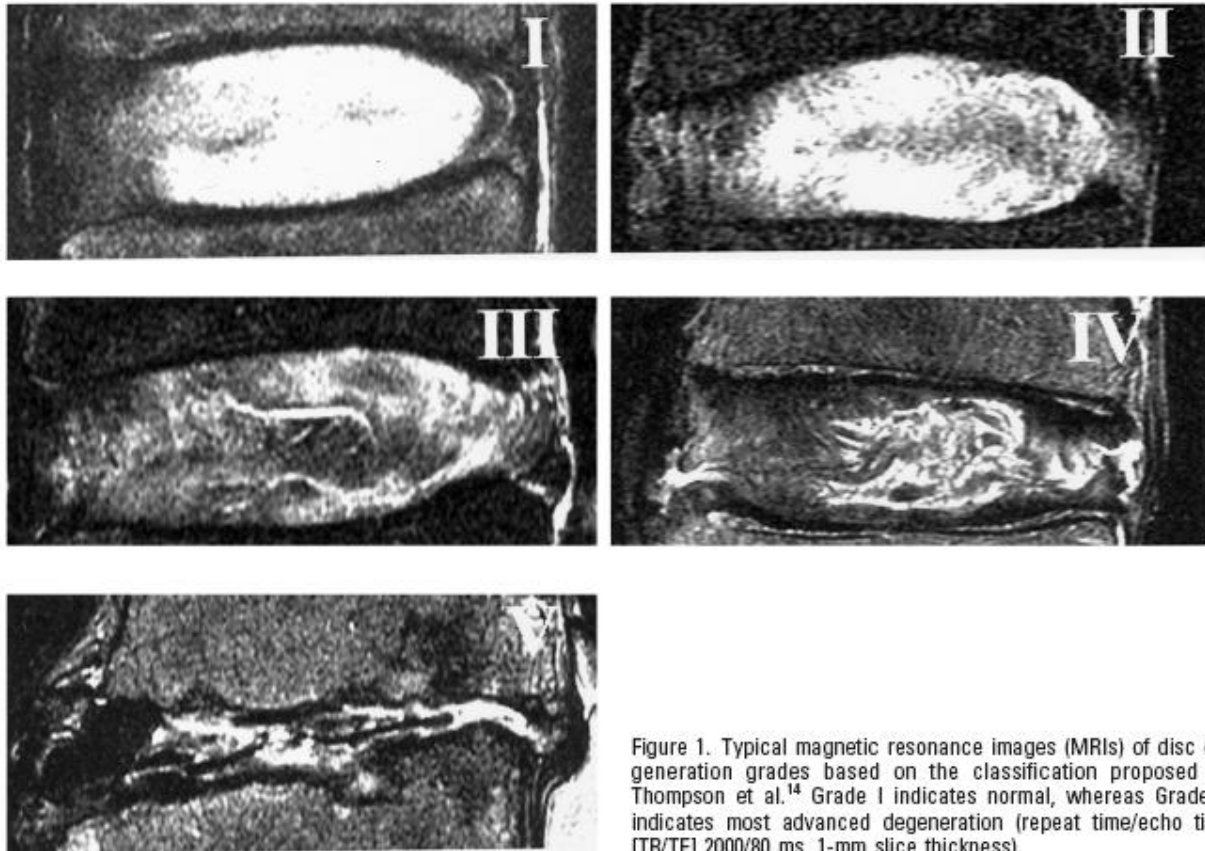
Typical magnetic resonance images (MRIs) of disc degeneration grades based on the classification proposed by Thompson et al.<sup>14</sup> Grade I indicates normal, whereas Grade V indicates most advanced degeneration (repeat time/echo time [TR/TE] 2000/80 ms, 1-mm slice thickness).
